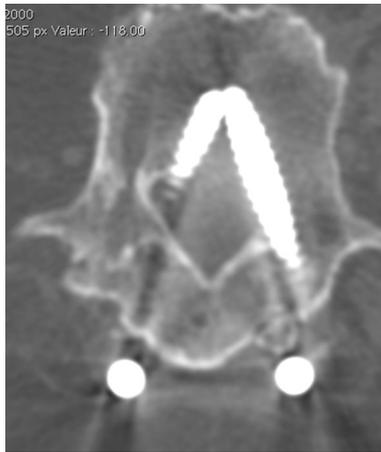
A preoperative CT-scan is essential for preoperative planning. In this figure, we can observe two misplaced screws, the presence of a fusion mass, the absence of laminectomy, the absence of facet joints that are completely fused and the presence of both transverse processes
